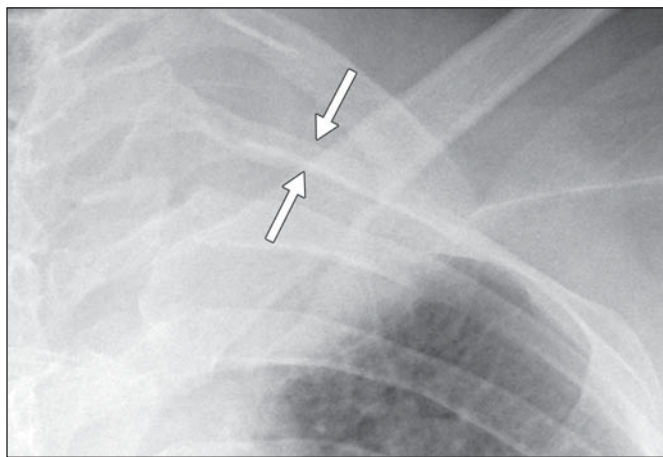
24-year-old man with neurofibromatosis type 1. Anteroposterior radiograph of ribs shows thinning of second rib posteriorly, "ribbon rib" appearance (*arrows*).
